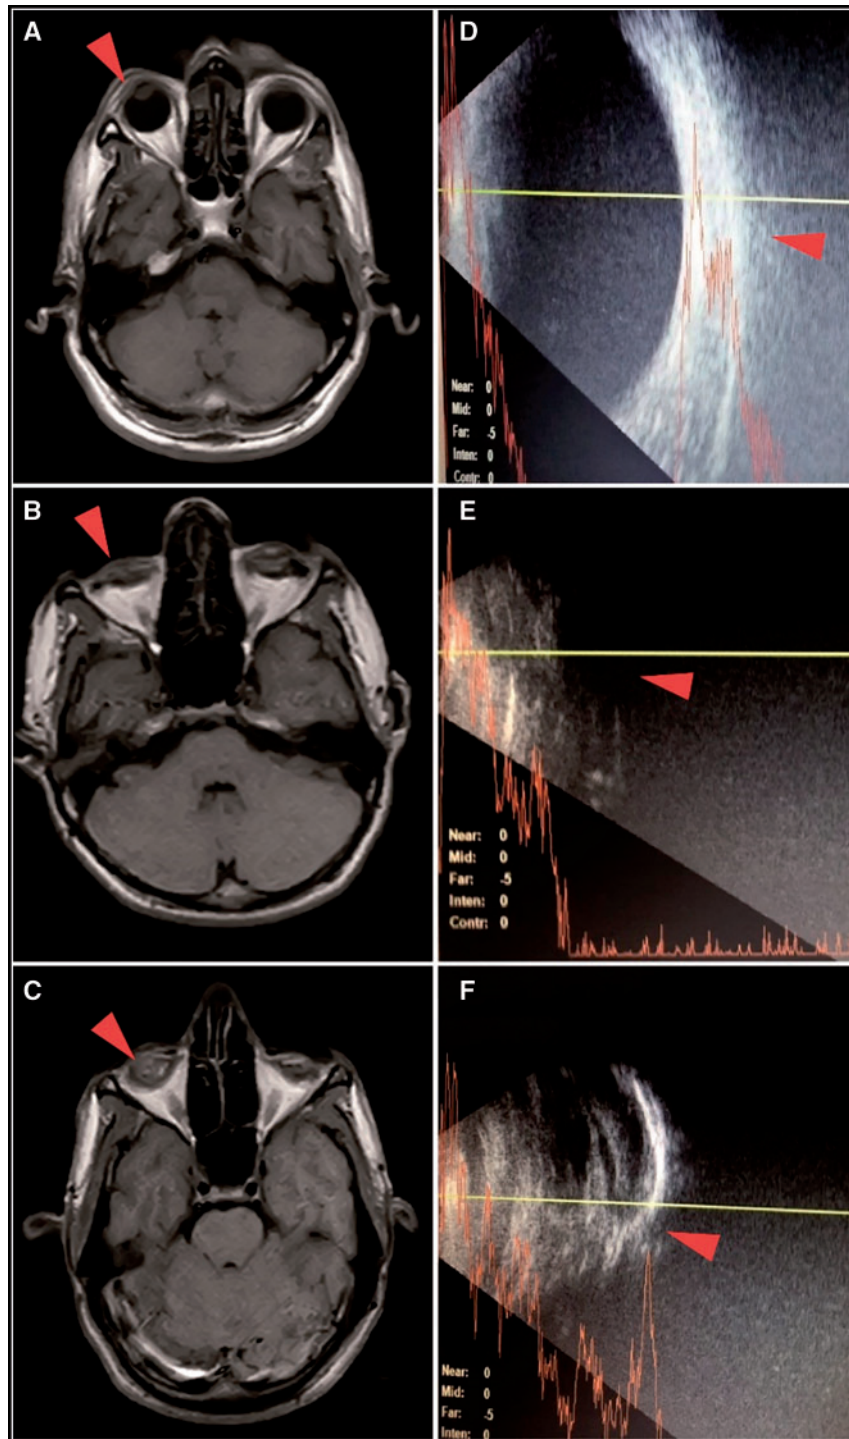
MRI and B-scans of two affected individuals (V: 2 and V: 3). B and C: T1 weighted MRI images of patients V: 2 and V: 3, respectively, arrows indicate the shrunken eye globes; A is the representative MRI image with normal eye globes. E and F are the B-scan images of patients V: 2 and V: 3, respectively, showing abnormal eye globe; D is a representative B-scan of a normal eye.
